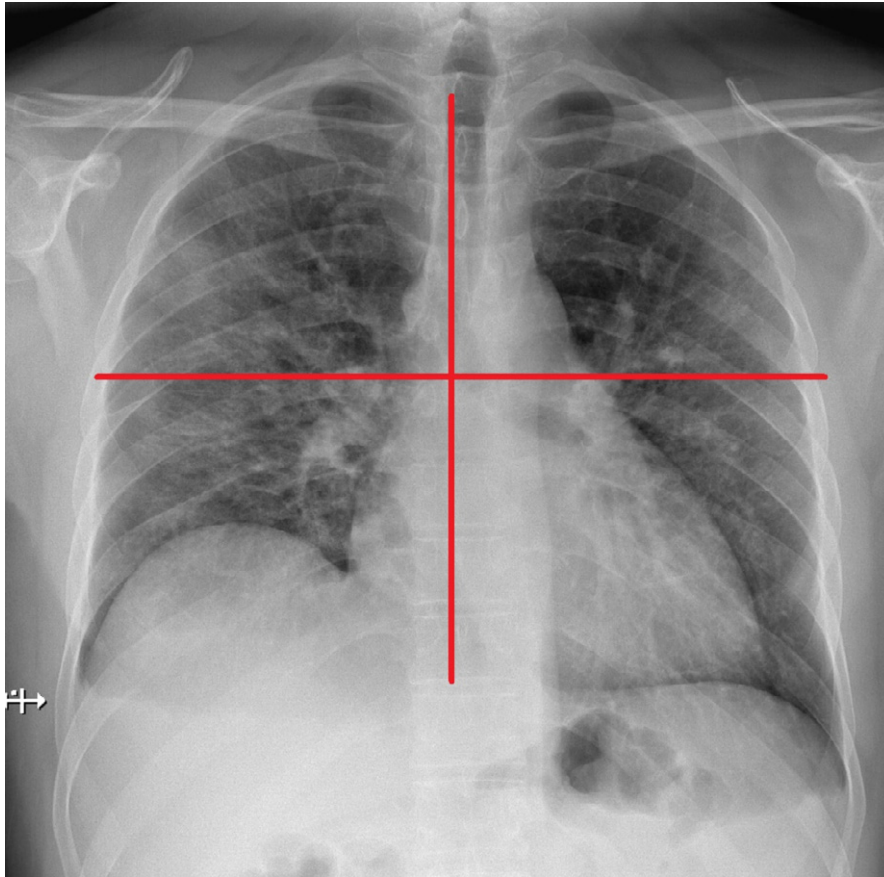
Chest radiography scoring: in a 50-year-old patient with RT-PCR proven coronavirus disease 2019 who was hospitalized but not admitted to the ICU. Chest radiography scoring was as follows: right upper lung zone mild/moderate involvement (1 point), the right lower lung zone mild/moderate involvement (1 points), as well as for the left upper and lower lung zones mild/moderate involvement (both 1 point), resulting in a cumulative score of 4.
